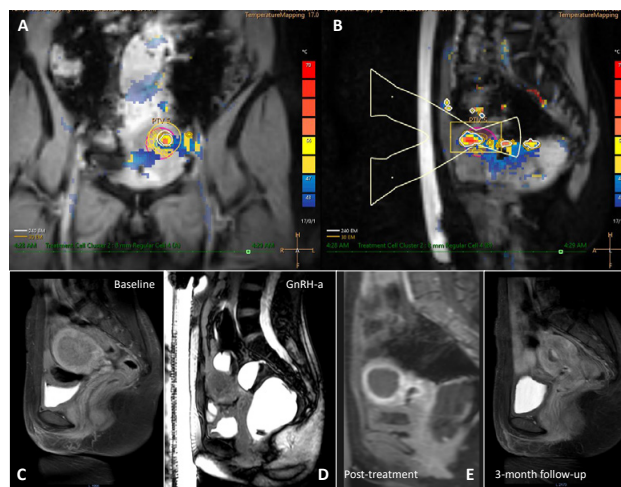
Temperature map acquired during the treatment (A, B). T2-weighted image upon patient screening was shown in (C). The size of uterus reduced after 2 courses of GnRH-a (D). Post-treatment CE T1-weighted images and follow-up at 3-months shown in (E) and (F).
